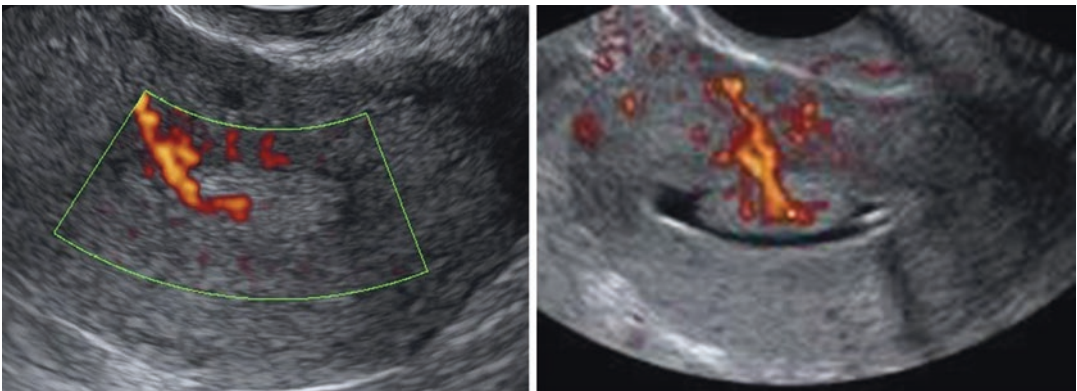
Power Doppler image of an endometrial polyp with a distinct dominant vessel at unenhanced ultrasonography (left) and at hydrosonegography (right)
